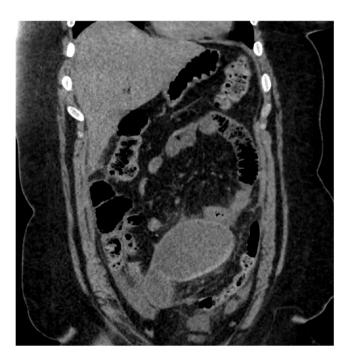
Day 2: CT Abdomen/Pelvis ordered by Emergency Department, showed increasing inflammatory process in the pelvis surrounding the reconstructed vagina.
